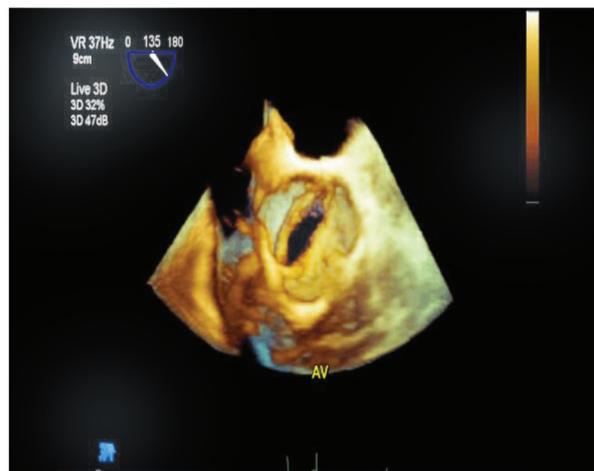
Live three-dimensional transesophageal echocardiogram showing enface view of a bicuspid aortic valve with fusion of the right and left coronary cusps.
